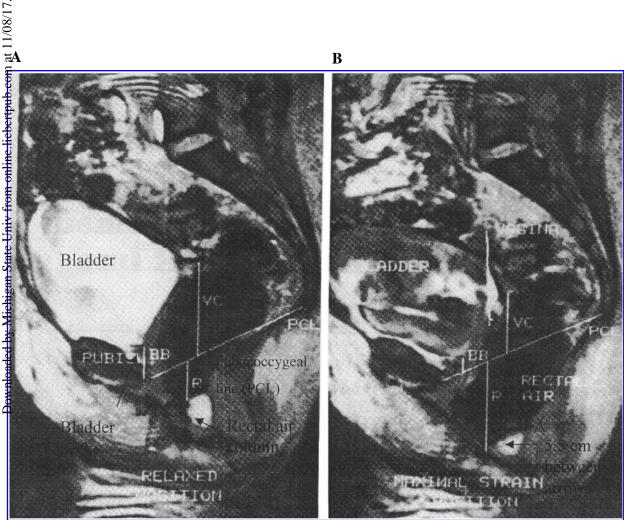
Sagittal dynamic MR images of woman with urinary and fecal incontinence. (A) Relaxed. (B) During maximum strain. Vertical distance from pubcoccygeal line to rectal air column is 5.5 cm, demonstrating rectocele. (Reprinted with permission from Yang A, Mostwin JL, Rosenshein NB, et al. Pelvic floor descent in women: Dynamic evaluation with fast MR imaging and cinematic display. Radiology 1991;179:25-33.)
